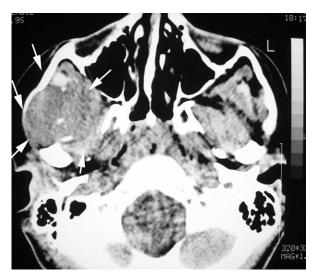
Computed tomographic image shows a large homogeneous mass (*arrows*).
